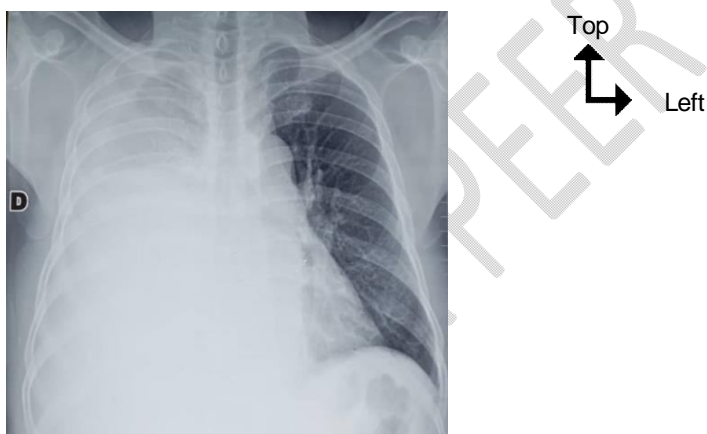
Frontal upright chest X-ray showing homogeneous opacity without air bronchogram occupying almost the entire right hemithorax, suggesting pleurisy of great abundance.
